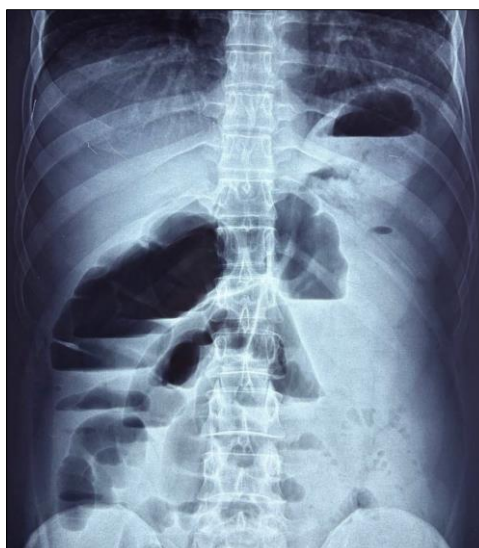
Erect abdominal X-ray.
